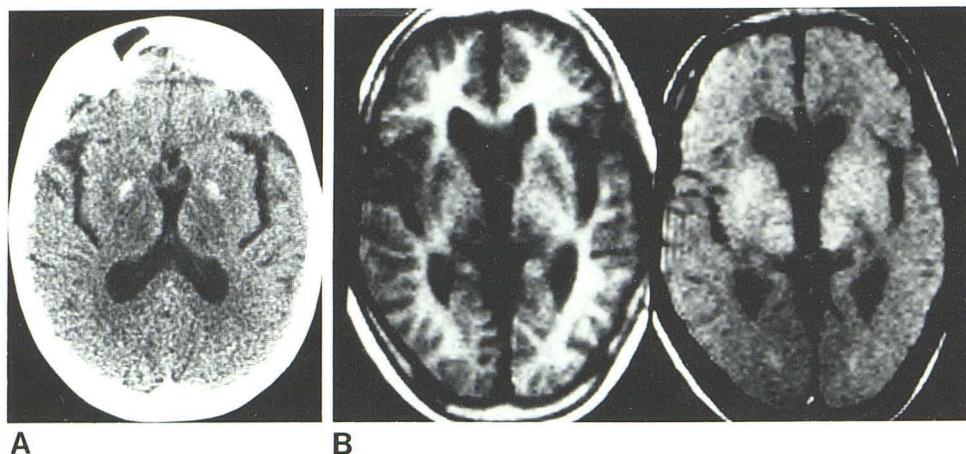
Wilson disease. A, CT shows generalized hypodensity in basal ganglia with punctate calcification. B, NMR images at comparable level in basal ganglia (slight difference in patient positioning compared with A) fail to depict punctate calcification. However, IR image (left) reveals characteristic degenerative change in lenticular nuclei, seen as low-intensity crescents, and similar abnormal intensity in thalami. SE image (right) shows abnormalities as high-intensity regions.
